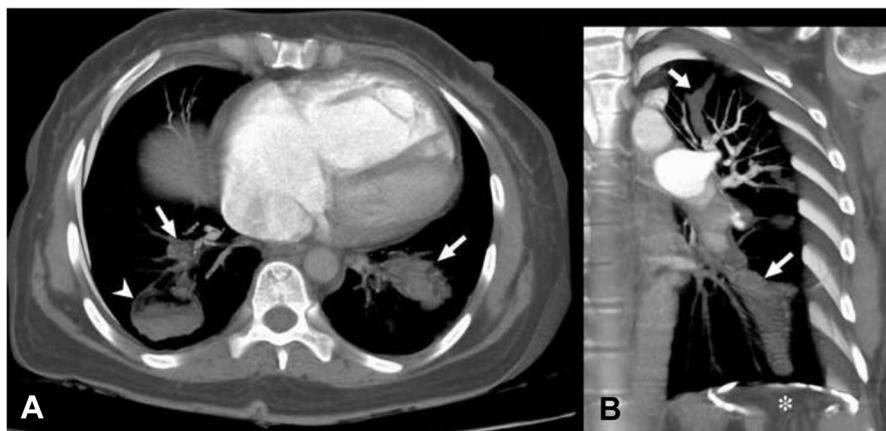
Axial (A) and coronal (B) volume rendering reconstructions of pulmonary computed tomographic angiography in a 49-year-old woman with hemoptysis show cystic filling defects and arterial luminal expansion in pulmonary arteries (arrows in A and B). There is also a cystic lesion containing air-fluid level with undulating surface (water lily sign) in the lower lobe of the right lung (arrowhead in A). Also note a subdiaphragmatic cystic lesion with calcified wall on the left side (asterisk in B). These findings suggest hydatid pulmonary embolism.
